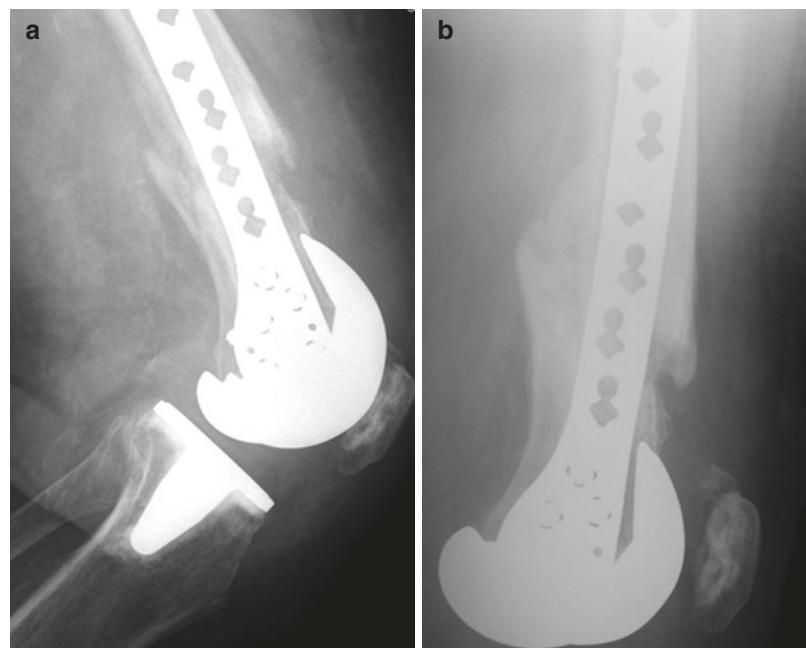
Lateral postoperative radiographs showing distal femoral fracture at (a) 3 months and (b) 6 months with abundant callus formation
